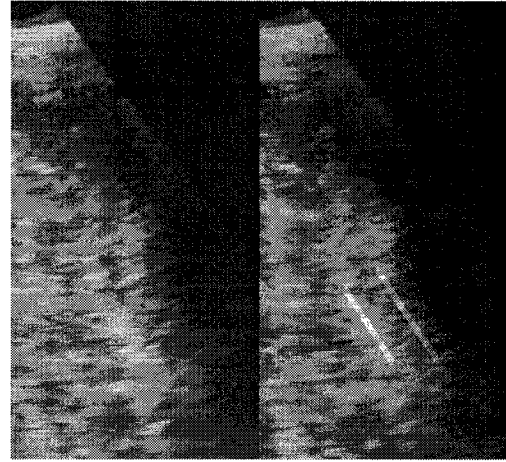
Left side of a patient's cranial sonogram. Right image demonstrates the location of the choroid plexus and white matter masks.
